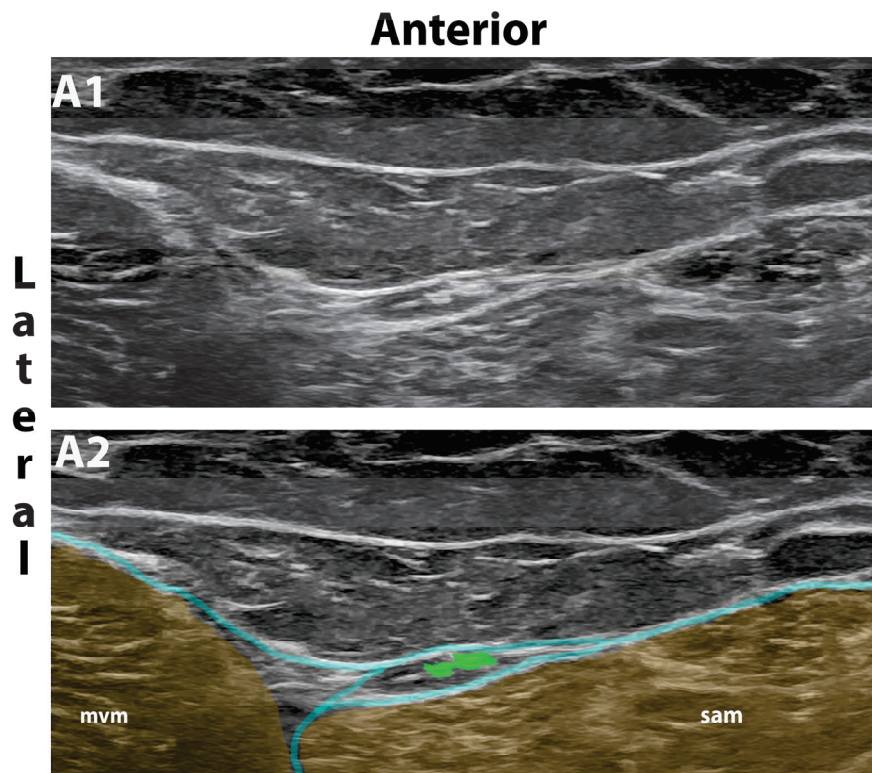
Distal MFCN-A block used in cadavers. Ultrasound image without (A1) and with (A2) color overlay showing a more distal approach to the selective MFCN-A block compared to Figure 1. The MFCN-A (green dots) is often more easily seen at this distal level approximately at the level of the base of the patella and was therefore used in cadavers where visualization was difficult. The distal approach is not advisable in patients because the MFCN-A has often split into several branches at this level. Mvm, medial vastus muscle; sam, sartorius muscle; fascia lata, cyan lines.
